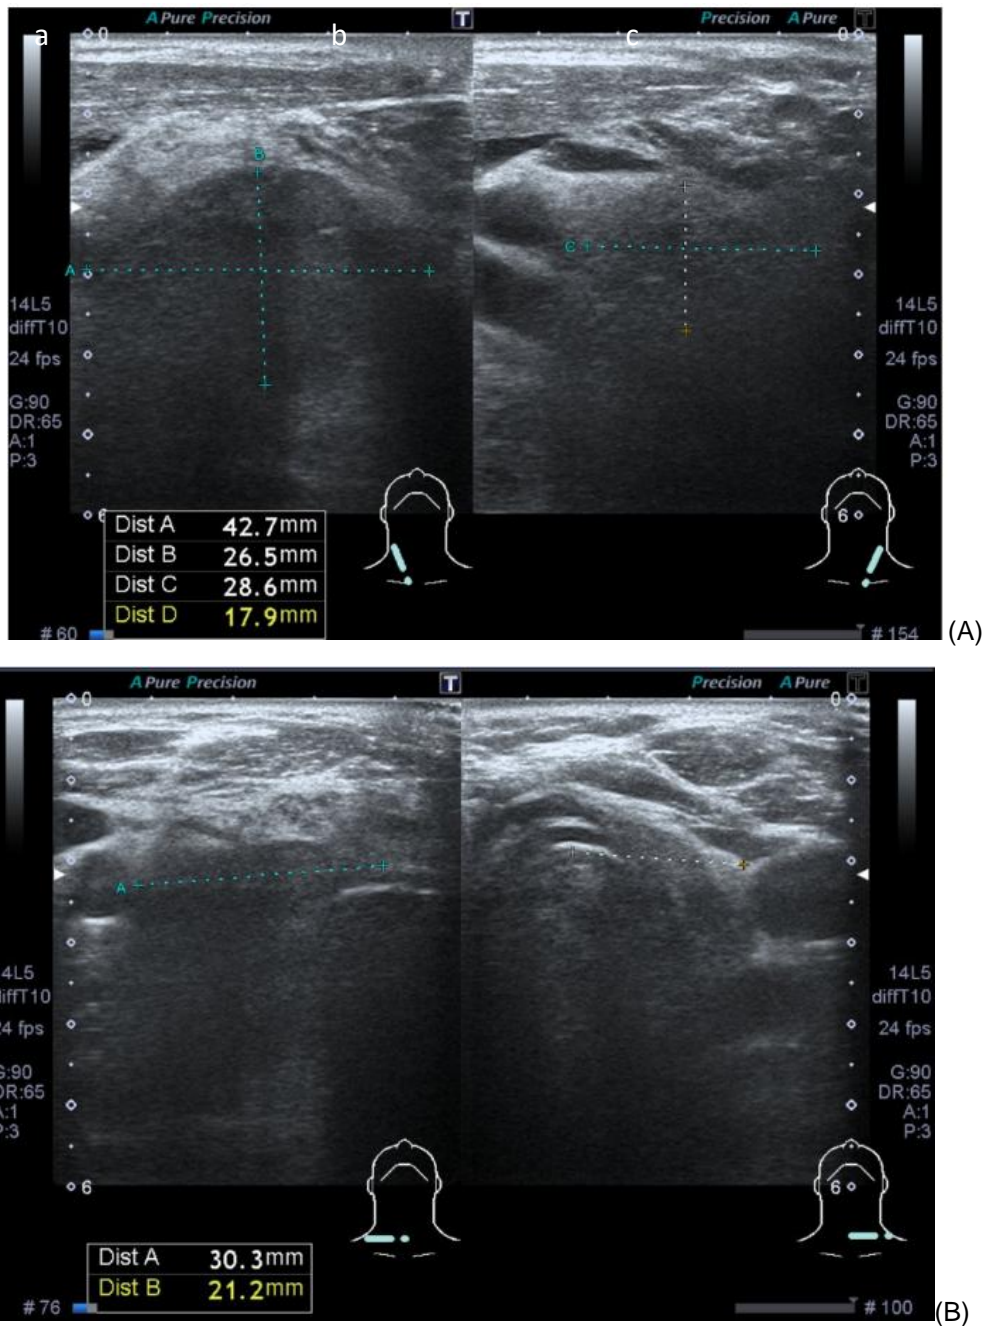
Ultrasound of the thyroid in April 2024. The bilateral lobes of the thyroid appeared hypoechoic and heterogeneous, findings compatible with residual tissue after thyroidectomy. (A) Longitudinal view. (B) Transverse view.
